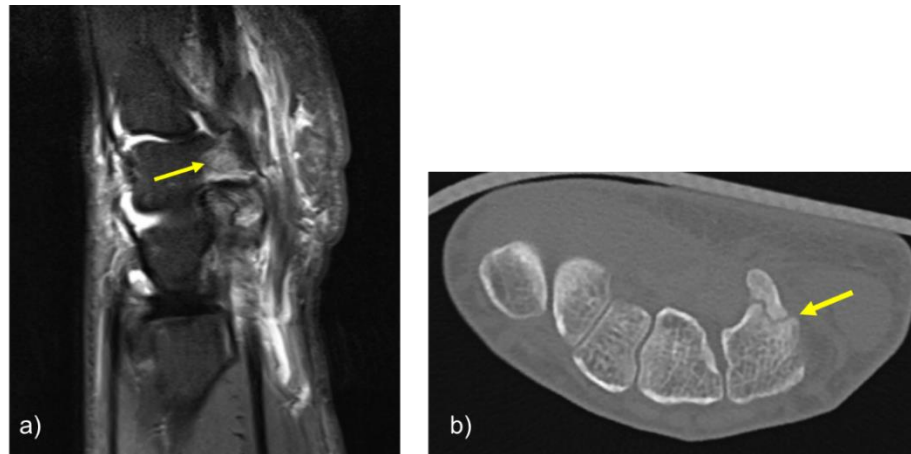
(a) Bone oedema seen in the hook of the hamate on original sagittal MRI; and (b) hook of hamate fracture demonstrated in wrist CT.
